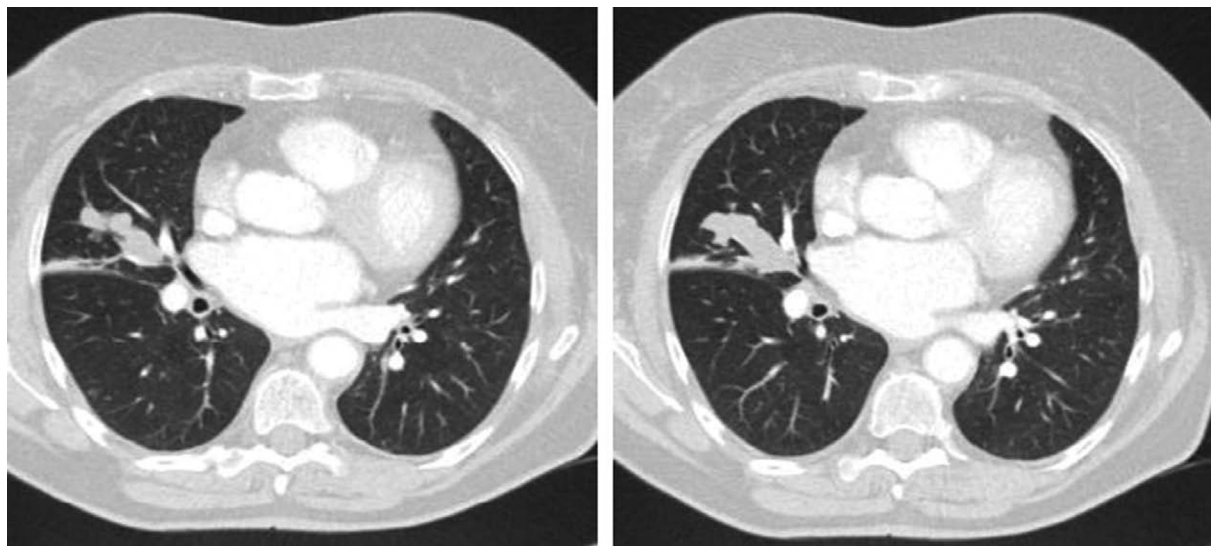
Computed tomography of the thorax demonstrating an intraluminal, elongated opacity in the lateral segment of the right middle lobe.
